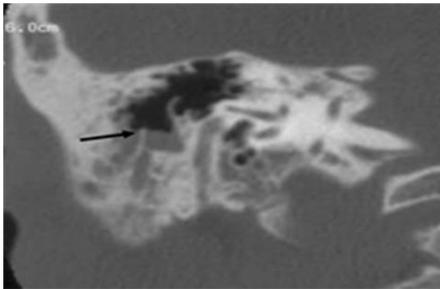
Middle ear effusion. Potential coronal CT scan right temporal showing multiple air fluid levels (arrows)
